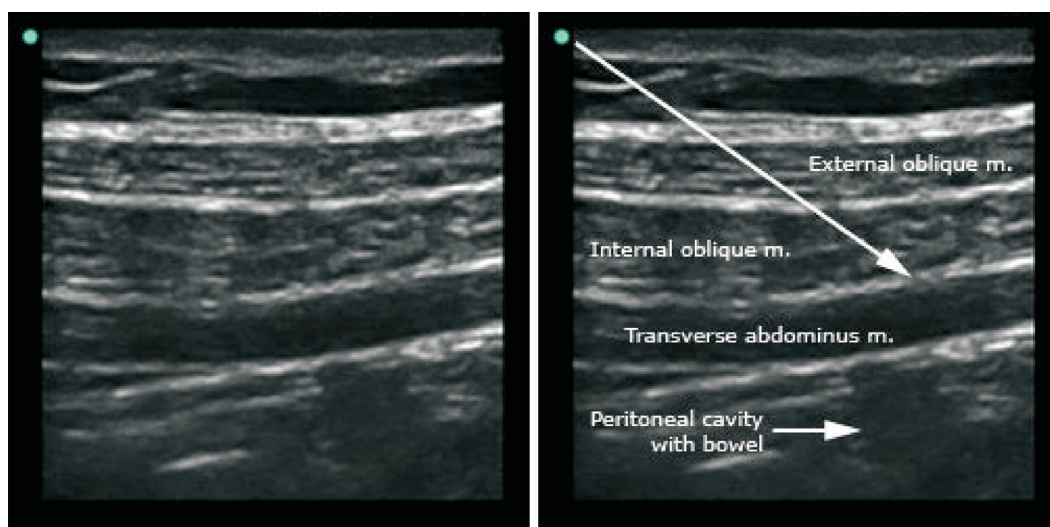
Sonographic view of the three lateral abdominal muscles. The orientation of the probe was perpendicular to a line joining the anterior superior iliac spine and the inferior rib to obtain a transverse view of the abdominal layers.
